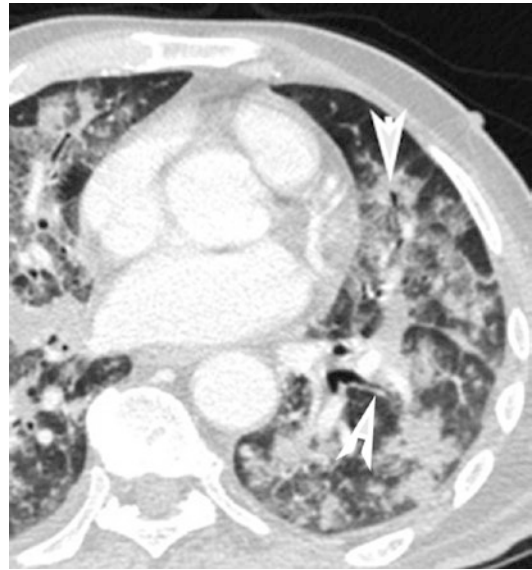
CT axial scan of the chest demonstrates air bronchogram (*arrowheads*) within patchy ground-glass pulmonary opacities
